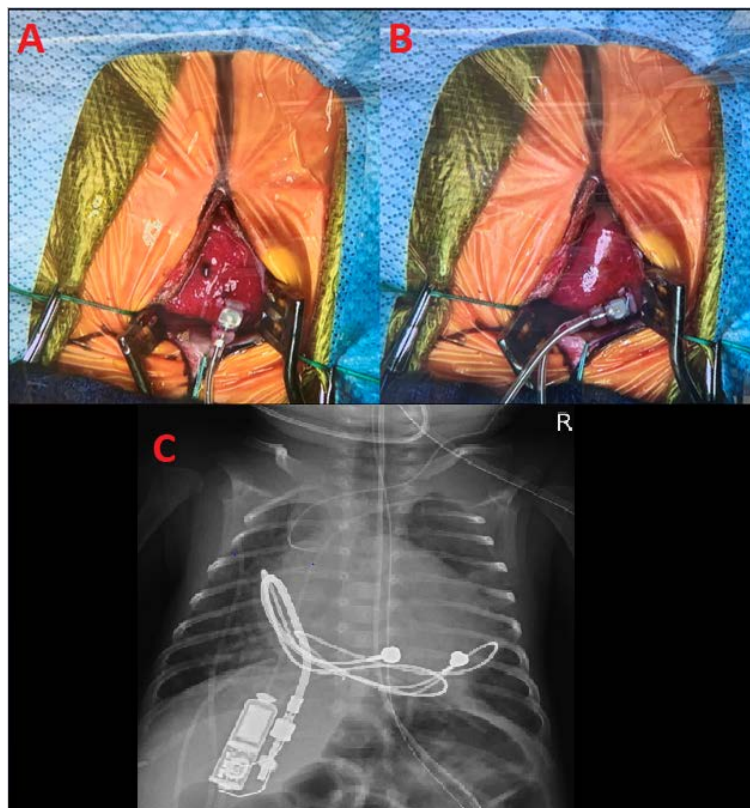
Sternotomy at the time of implantation of an epicardial single chamber pacemaker in a premature infant with CCAVB (head at the top). (A) Implantation of the cathode of the epicardial Medtronic CapSure™ EPI Model 4968 pacing lead on the left ventricular apex, and (B) anode implanted on the right ventricular free wall. (C) Post-operative chest radiograph demonstrating a bipolar ventricular epicardial lead connected to the abdominal Pediatric IPG pacemaker.
